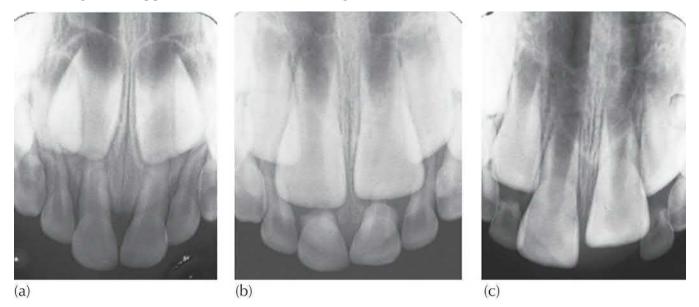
(a) Periapical view of normal incisors at age 3 years. Note the degree of overlap of unerupted permanent central incisors and lateral incisors. (b) The same patient at age 5 years. The central incisors have migrated inferiorly and labially relative to the lateral incisor and the reduced degree of overlap. (c) At 6.5 years the central incisors are erupting. The lateral incisors have migrated labially into the arch to completely eliminate the overlap.
